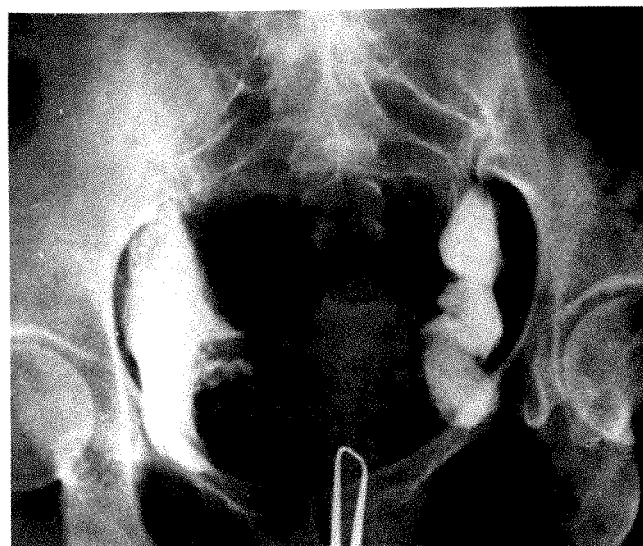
Radiograph taken immediately after injection of colloidal gold suspended in 20% diodrast to demonstrate distribution of colloid. (Reprinted with permission from [6])
